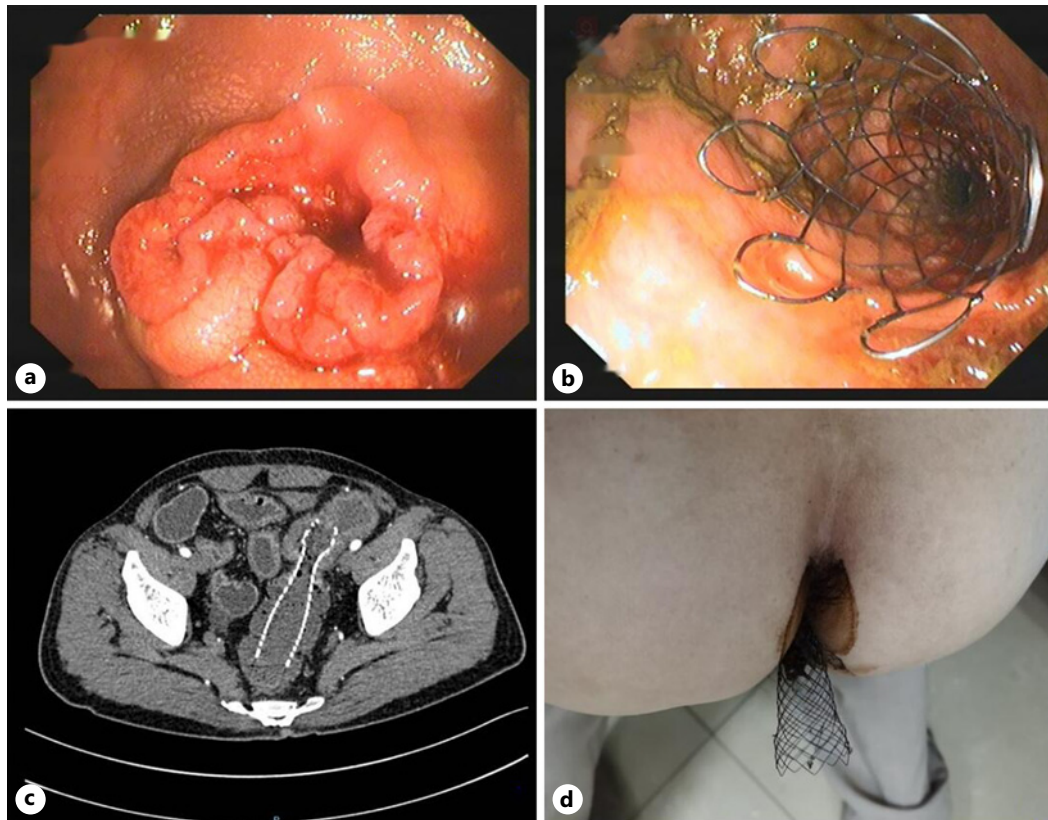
a An obstructing distal sigmoid colon adenocarcinoma was found by the colonoscopy. b The uncovered self-expandable metal stent was placed. c Abdominal CT obtained 24 h after stent deployment. d Half of the stent was outside the anus.
